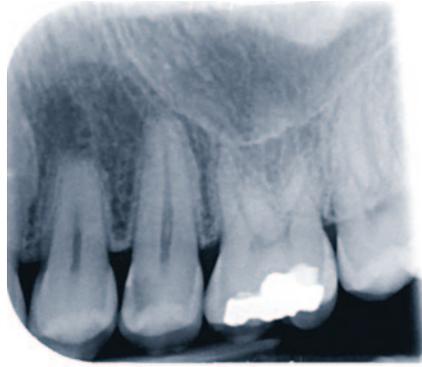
Clinical and radiographic appearance of a carious lesion – can we accurately describe how deep this lesion is?
